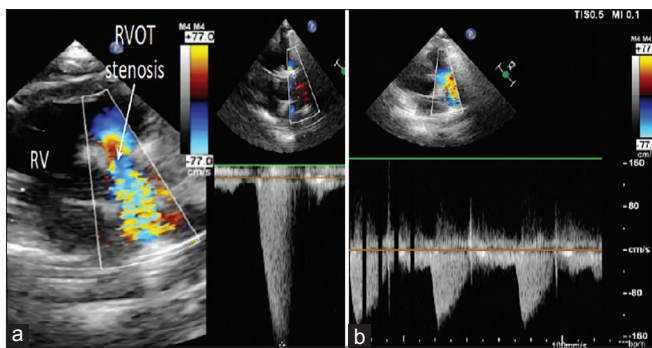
(a) Transthoracic echocardiogram short-axis view before surgery, showing stenosis of the RV outflow tract, with a peak systolic velocity of 3.89 m/s. (b) Transthoracic echocardiogram after surgery, showing a peak systolic velocity of 1.5 m/s. RVOT: Right ventricular outflow tract, RV: Right ventricle
